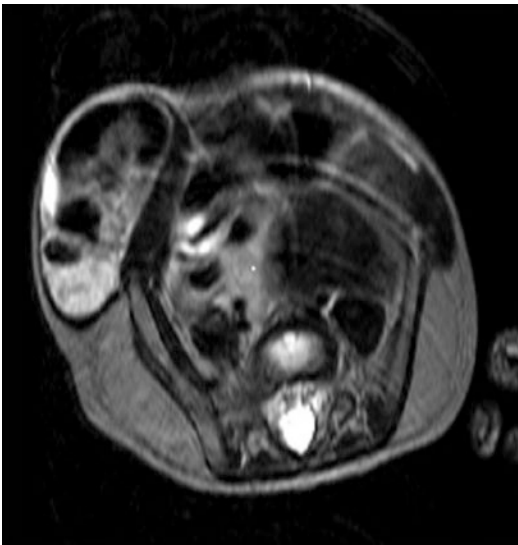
Spigelian hernia—6-month-old infant with increasing lateral hernia—MR imaging; T2-weighted sequence—Axial view. A lateral hernia containing bowel loops can be visualized at the right side
